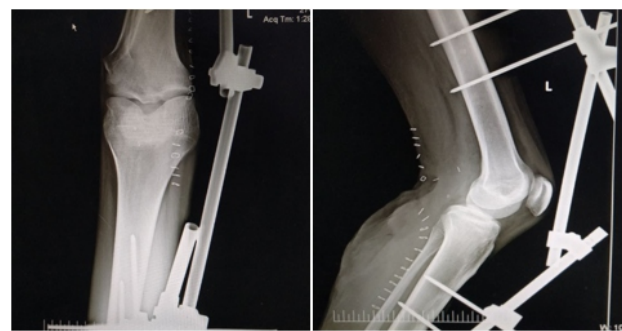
Post Operative Xray After Knee Reduction, Fasciotomy for Tense Leg Compartments, Vascular Repair, External Fixator Application.
